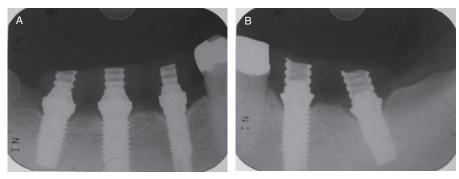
A* and *B*, radiographic view after completion of orthodontic intrusion. *A*, Control implants at sites 45, 46, and 47 after prosthetic abutments were placed. *B*, Anchor implants at sites 36 and 37. Perifixtural bone condensation was observed around the implants.
